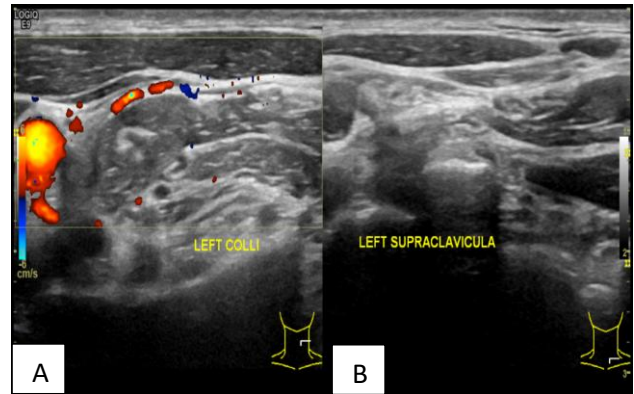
(A and B): Neck ultrasound of the patient.
